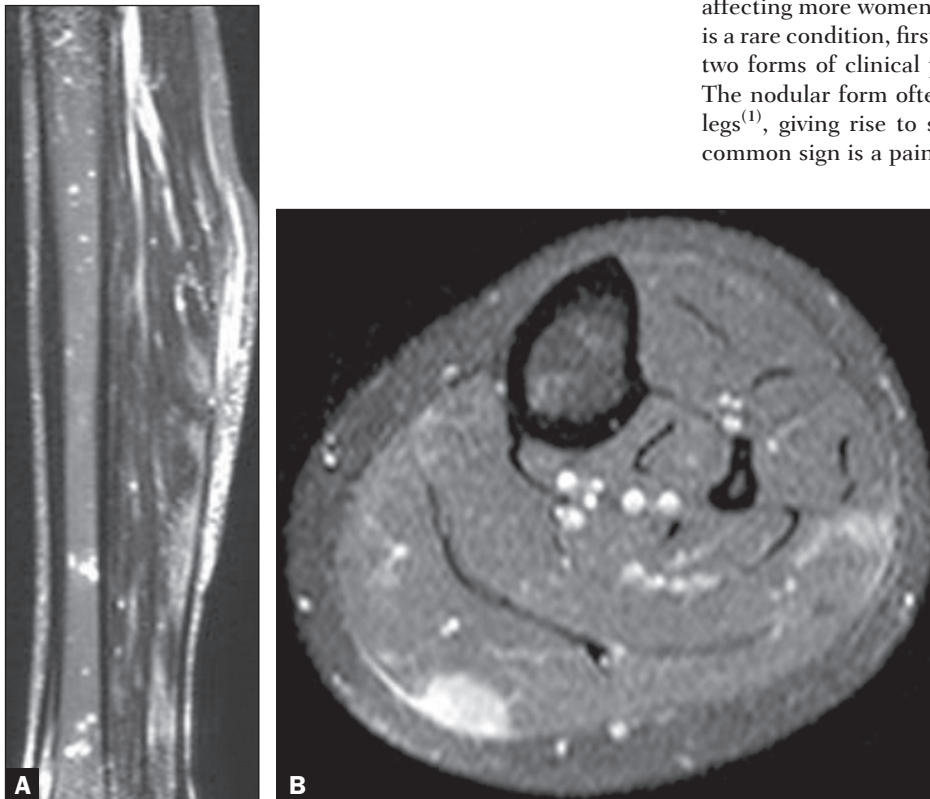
A: Non-contrast-enhanced STIR sequence showing nodules of high signal intensity, in the muscle and in the bone. B: Contrast-enhanced, fat-saturated T1-weighted sequence showing enhancement of the nodule to be biopsied.
